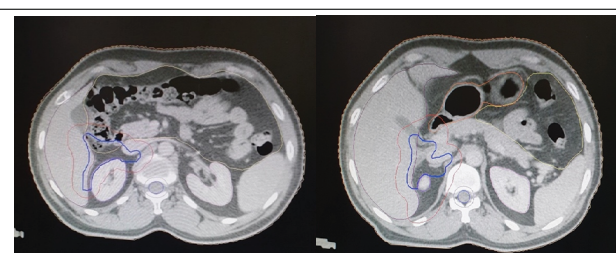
Contouring done on the planning CT scan.
